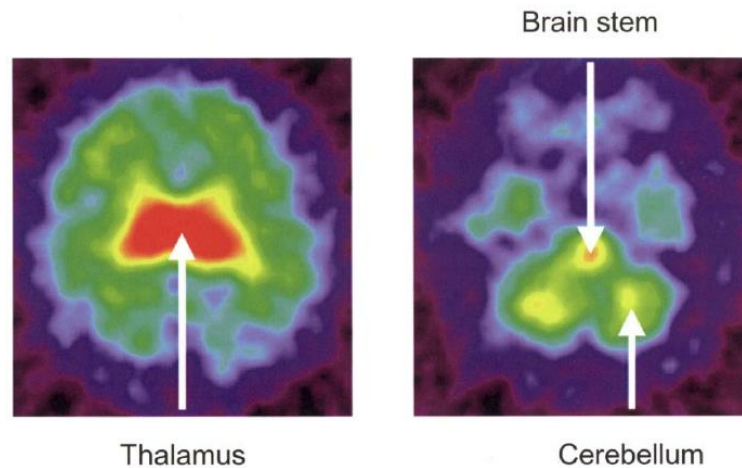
Shows The SPECT image of cerebellum
